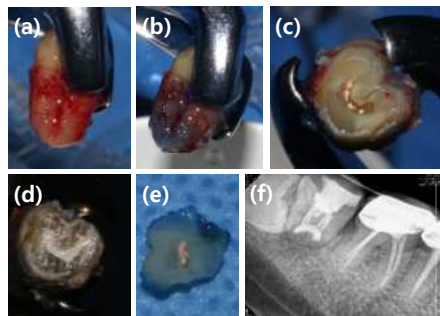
Intentional replantation procedure (a) #47 was carefully extracted using an extraction forcep (b) Root surface was dyed with methylene blue and rinsed to make sure there was no crack line (c) Root-end resection was done using tapered diamond bur. Retro-preparation using 330 tapered bur was made following original C-shaped canal and resin-wire splint delivered between #46,47 (d) Retrograde filling was done using putty-type MTA(One-Fil®Putty, MEDICLUS, Korea) (e) Other section of resected root-end segment (f) Periapical radiograph was taken after tooth replantation and resin-wire splint between #46,47
